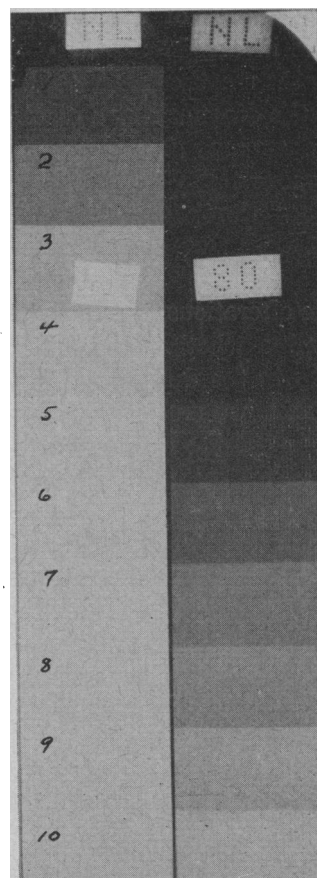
Shows us two radiographs of a step-ladder made of thin lead sheets. They were taken under different techniques, one intended to show mainly the thick and the other mainly the thin parts of the ladder. This they do quite successfully. No variation in ordinary visible lighting could possibly produce such a variation in the appearance of the same step-ladder. The number 80 on the right-hand half appears much closer to us than does the number 40 on the left, and the background of the 80 appears much further away from the 80 than the background of the 40 appears to be behind that figure; yet, both the 40 and the 80 and their respective backgrounds are all on the same plane. This is another example of the prepotence of the opaque. Proper technique is necessary to show up the 80 or the 40, as may be required. So, too, proper technique can show up radiographic changes which are confined to bone or are confined to the soft tissue on the other hand, or involve both the bone and the surrounding soft tissues. It is obvious that our normal visual impressions give us no help in such cases as were indicated in Figs. 9 and 10. They tend rather to confuse us unless complete mental analysis accompanies the interpretation of the visual impressions.
